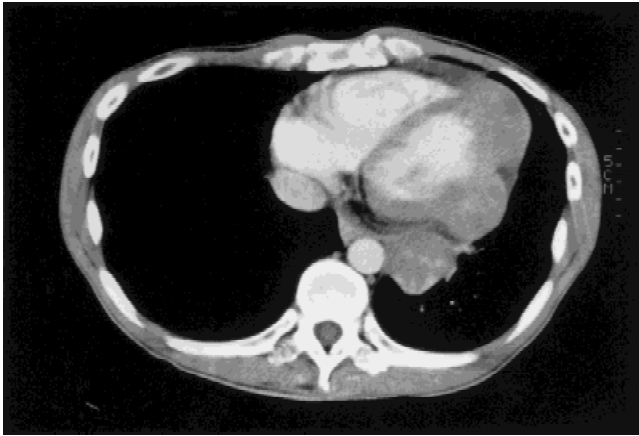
CT scan of the chest revealing soft tissue mass involving the left ventricle.
